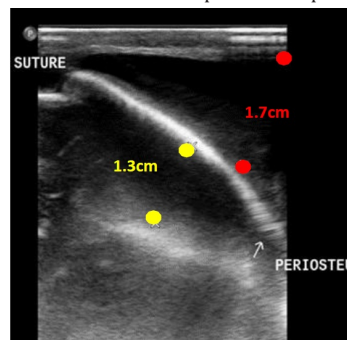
Ultrasound cranium showing left subgaleal hematoma (indicated by red dots) and left parietal cephalohematoma (indicated by yellow dots)
